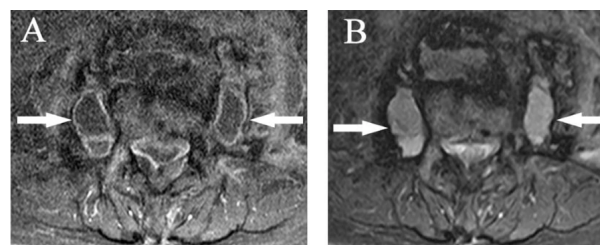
Previous magnetic resonance imaging (MRI) (3 months before). T1-weighted images with contrast medium injection (2A) showed rim-enhanced lesions in the bilateral psoas muscles, suggestive of abscesses (white arrows). T2-weighted images (B) showed hyperintense signal in the abscesses.
